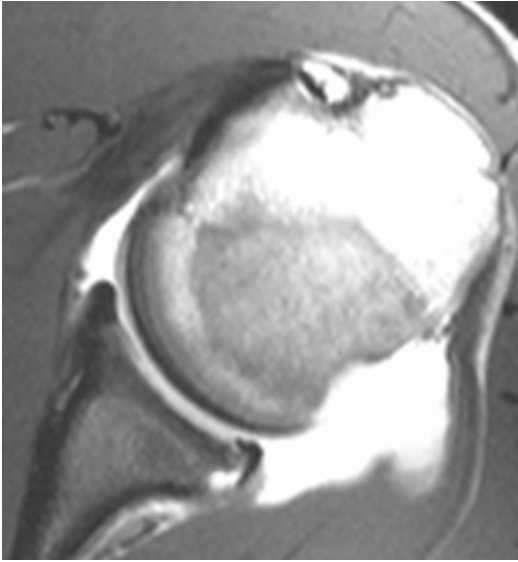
T2-weighted MRI arthrogram demonstrating posterior labral tear and Hill-Sachs lesion
